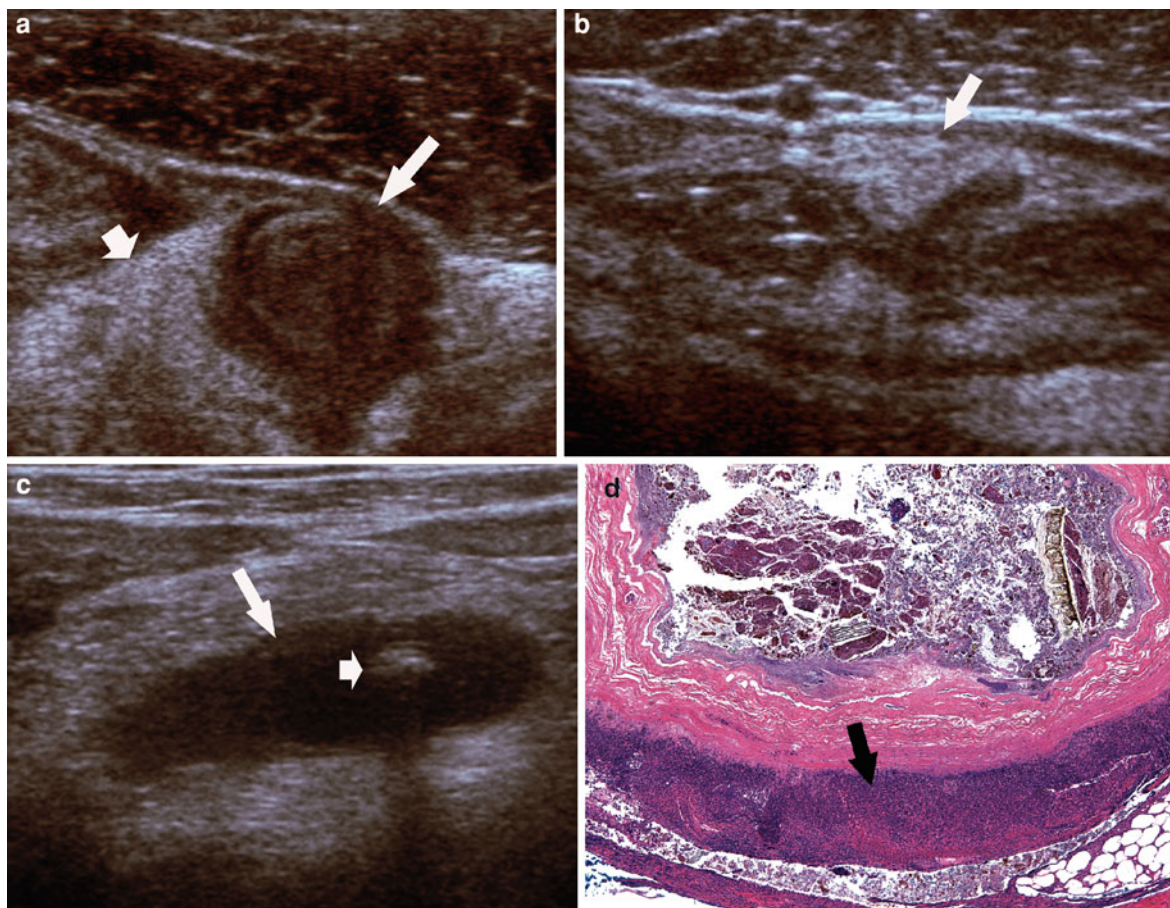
a, b, c, d Gangrenous appendicitis with focal loss of echogenic submucosal layer and cecal edema in two different patients. a is transverse sonogram of short axis of appendix demonstrating marked mural thickening and loss of echogenic submucosal layer (*long arrow*); note inflamed periappendiceal fat with increased echogenicity (*short arrow*). In b, transverse grayscale sonogram of cecum in same patient, note marked mural thickening with prominence of echogenic submucosal
